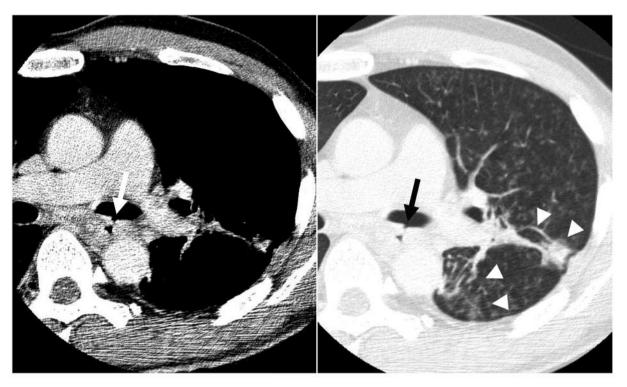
Computed tomography showing a fistula between the esophagus and left main bronchus (arrow) and pneumonia (arrowhead).
